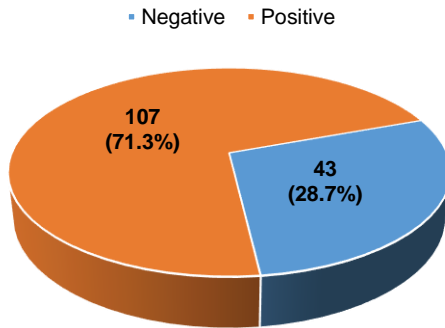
Distribution (frequency and percentage) of subjects by presence or absence of dermoid cyst on transabdominal sonography
